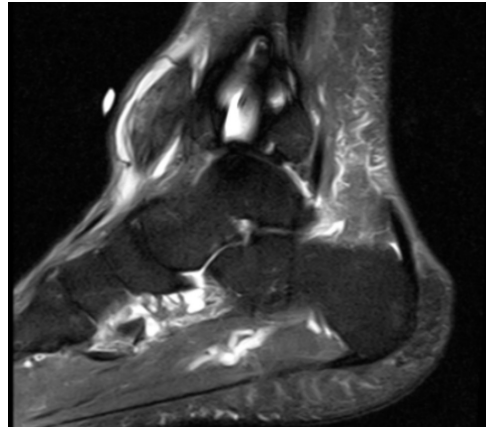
MRI of Left Lower Extremity Sagittal T2 view - lesion measures up to 2.0 x 2.0 x 4.1cm (AP X ML X CC), with large amounts of fluid in the tibialis anterior tendon sheath.
